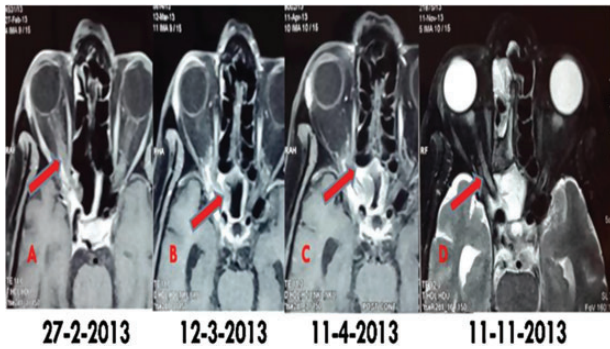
(A) T₁-weighted axial MRI showing minimal soft tissue at the right orbital apex abutting the right optic nerve. (B and C) T₁-weighted axial MRI showing increase in the size of the mass with bony erosion of sphenoid and ethmoid sinus. (D) T₂-weighted axial MRI revealing decrease in the size of the mass after 7 months of oral voriconazole.
